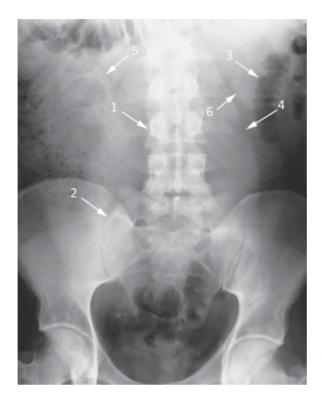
Anatomical landmarks on normal abdominal X-ray. 1 – lumbar spine; 2 – sacroiliac joints; 3 – gas in bowel; 4 – psoas shadow; 5 – right kidney; 6 – left kidney
